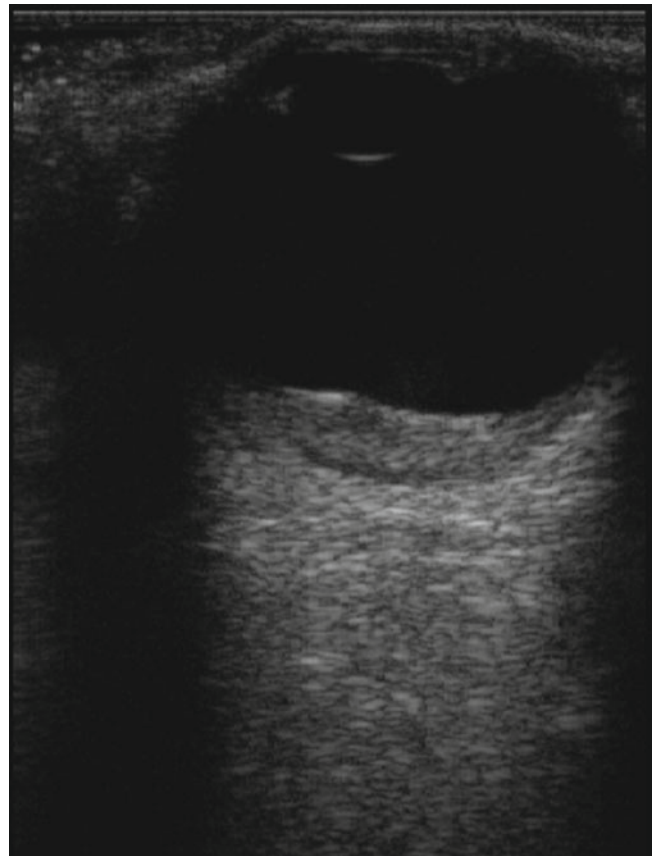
The same patient's ultrasound demonstrating the degree of thickening
